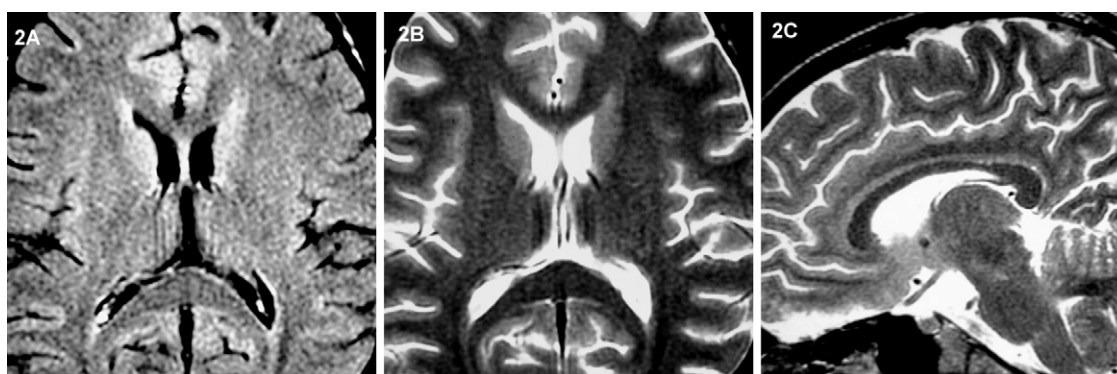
MRI of the brain after 4 weeks. (A) FLAIR, (B) axial T2-weighted, and (C) sagittal T2-weighted images showing complete resolution of the lesion in the central splenium of the corpus callosum.
